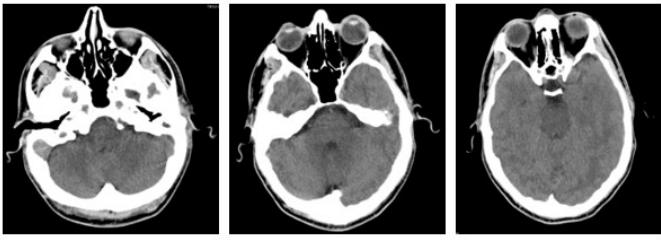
Brain CT imaging 5 days prior to diagnosis of pneumocephalus and brain abscess
